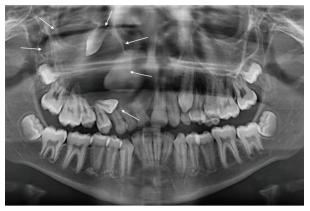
Panoramic X-Ray Imaging of Cyst
